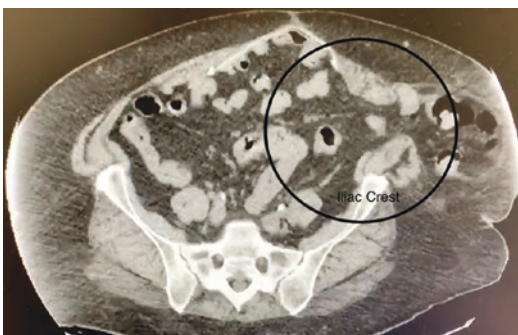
Computed tomography scan demonstrating a true left flank hernia with a bowel protruding through the fascial defect ©Photo produced by William W. Hope, MD, 2019
